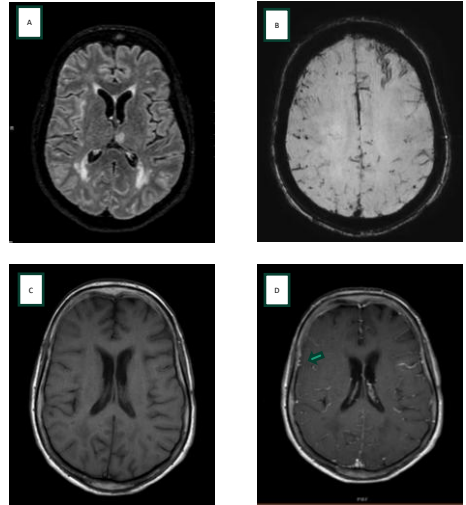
MRI images at baseline. Panel A: axial FLAIR sequence showing white matter hyperintensities in posterior periventricular and subcortical regions and in left thalamus; Panel B: axial SWI showing left frontal cortical siderosis (arrow) and multiple lobar haemorrhages; Panel C: T1 pre contrast; Panel D: T1 post contrast showing multiple sulcal leptomeningeal enhancement
